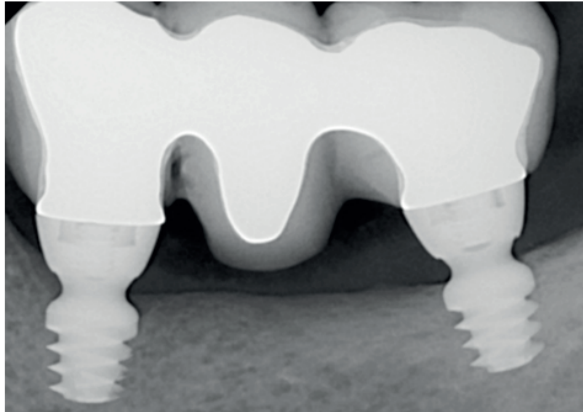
Radiograph taken 2 years after functional loading of two ultra-short dental implants placed in a resorbed posterior mandible. (Hartman M., 2018)
